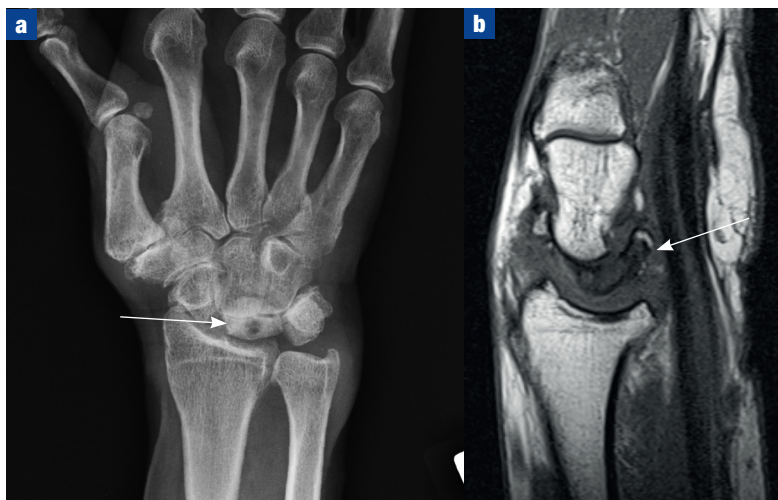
a. Anteroposterior radiograph of the wrist demonstrating Kienböck's disease. The lunate is sclerotic and small in size (arrow). There is a negative ulnar variance and incidental osteoarthritis at the base of the thumb metacarpal. b. Sagittal magnetic resonance image T1 sequence of the wrist in advanced Kienböck's disease (same patient). The lunate is low signal indicating sclerosis, and is fragmented with loss of the normal moon-shaped morphology (arrow).
